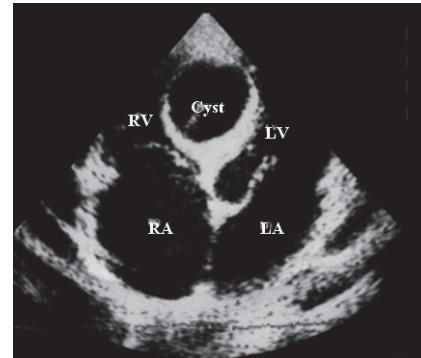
Apical 4 chamber view showing the hydatid cyst at the interventricular septum measuring 30 x 30 mm before treatment, RV - right ventricle, LV - left ventricle, RA - right atrium, LA - left atrium
